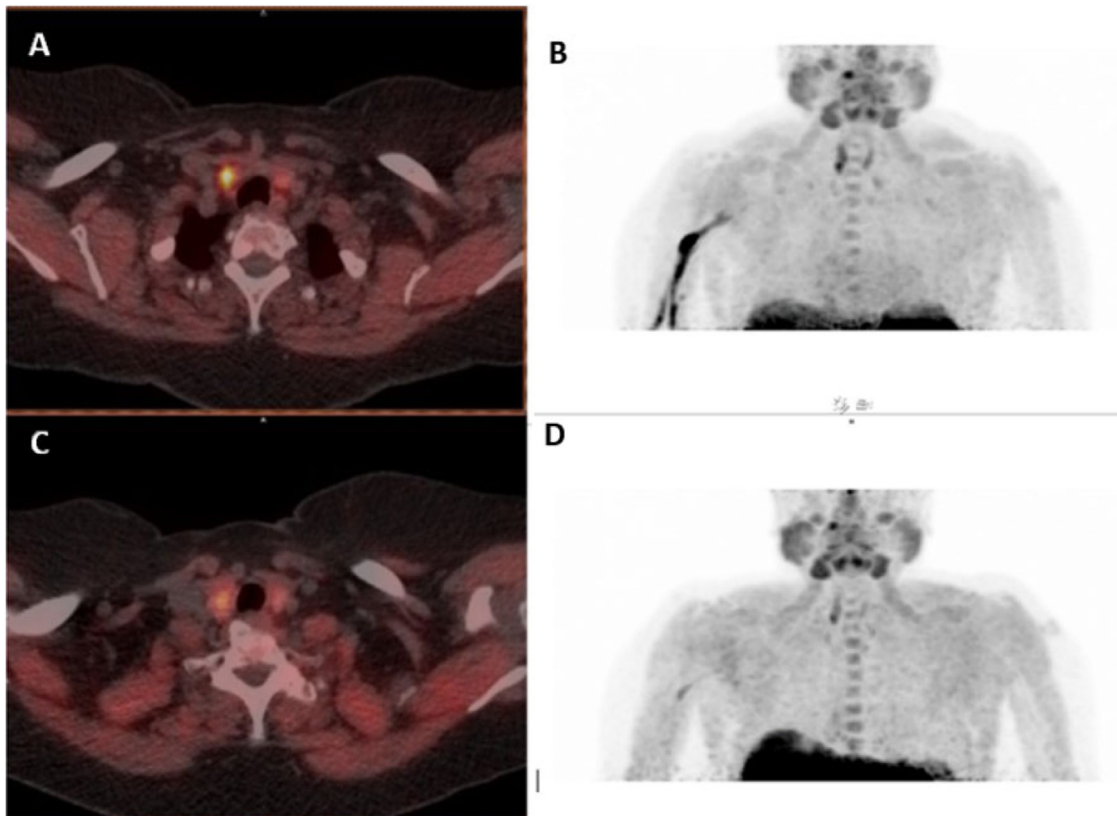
Right inferior pathologic parathyroid gland. A, B: early images. C, D: delayed images. A, C: axial PET/CT fusion images. B, D: maximum intensity projection (MIP) images. Focal uptake of ¹⁸F-FCH located inferior to the right thyroid lobe with greater uptake in the early images (A, B).
